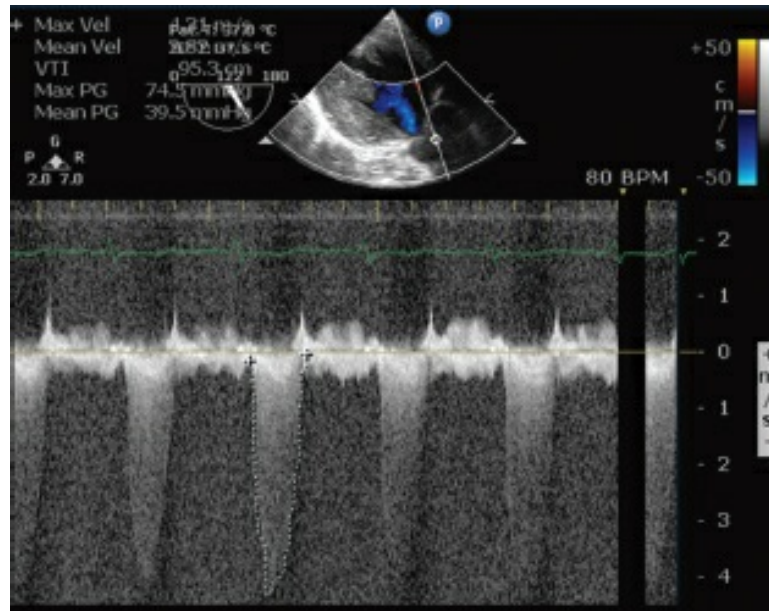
Trans-gastric view showing continuous wave spectral Doppler across the aortic valve with a flow velocity of around 4 m/s giving a peak gradient of around 64 mm Hg.
